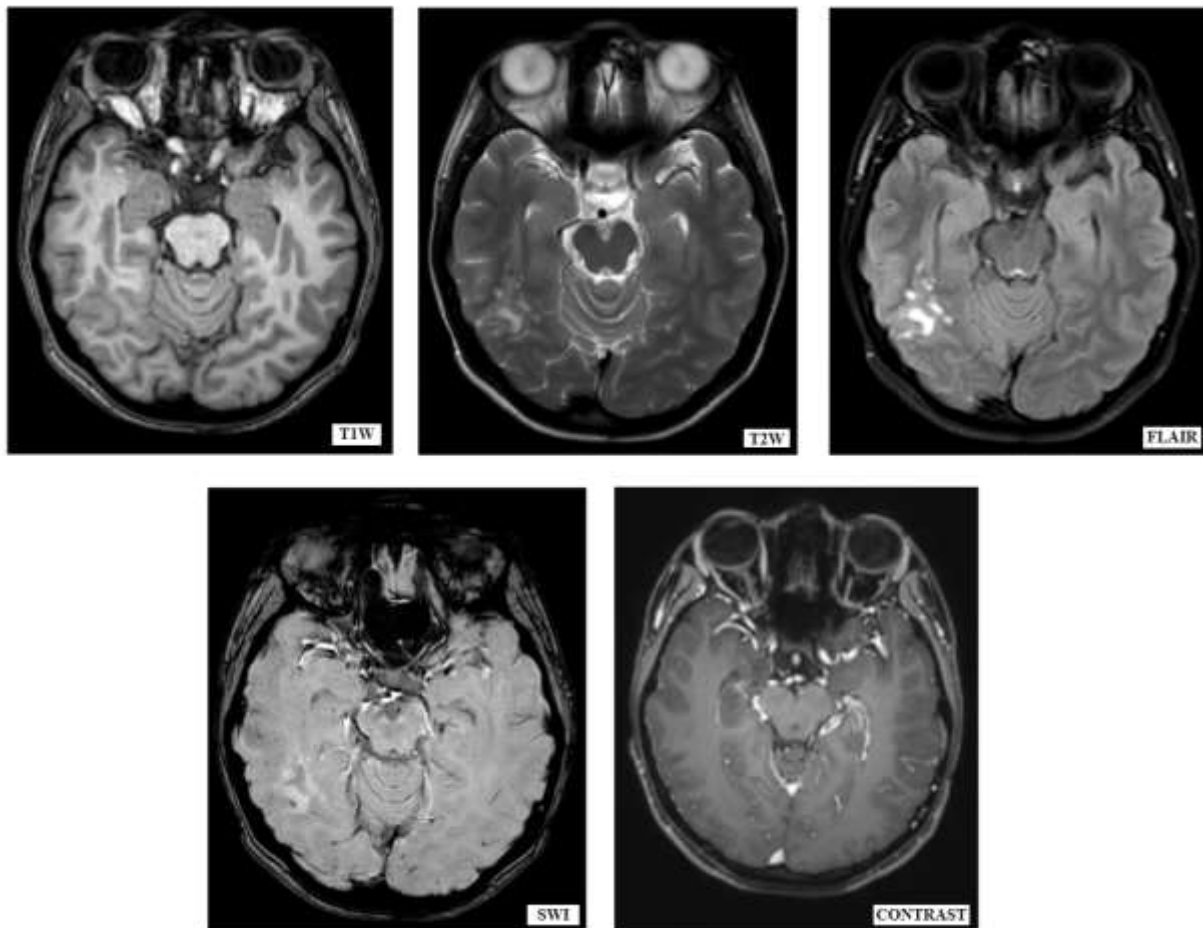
MRI Brain plain and contrast of the patient that shows a cluster of coalescent nodules in the posterior aspect of right temporal and right temporo-parietal lobes.
